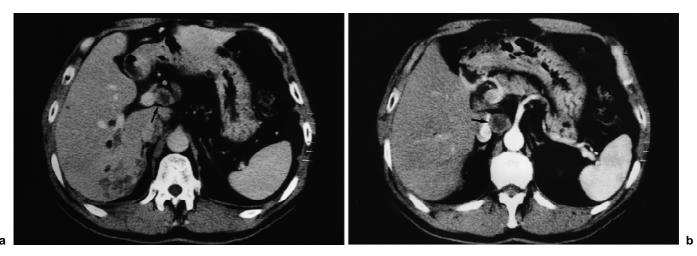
Contrast-enhanced computed tomography revealed an enlarged diaphragmatic lymph node in the right thoracic cavity (*arrow*)
